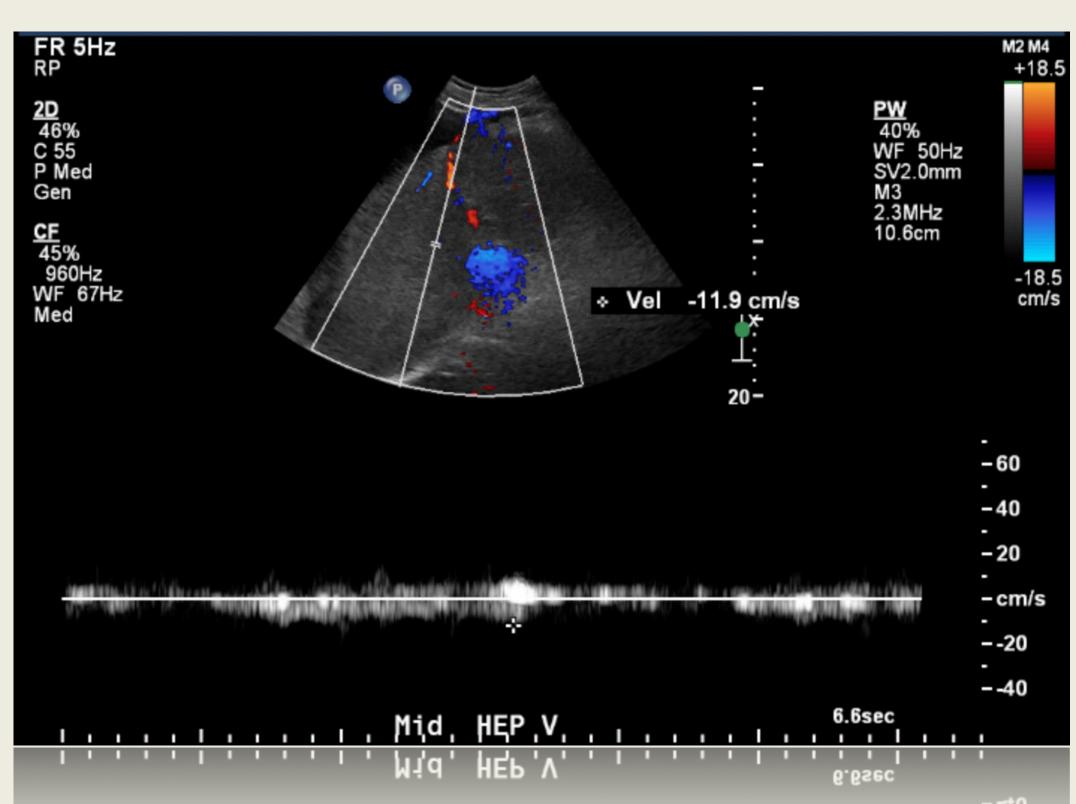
US with doppler showing attenuated middle hepatic vein with reduced flow velocity
